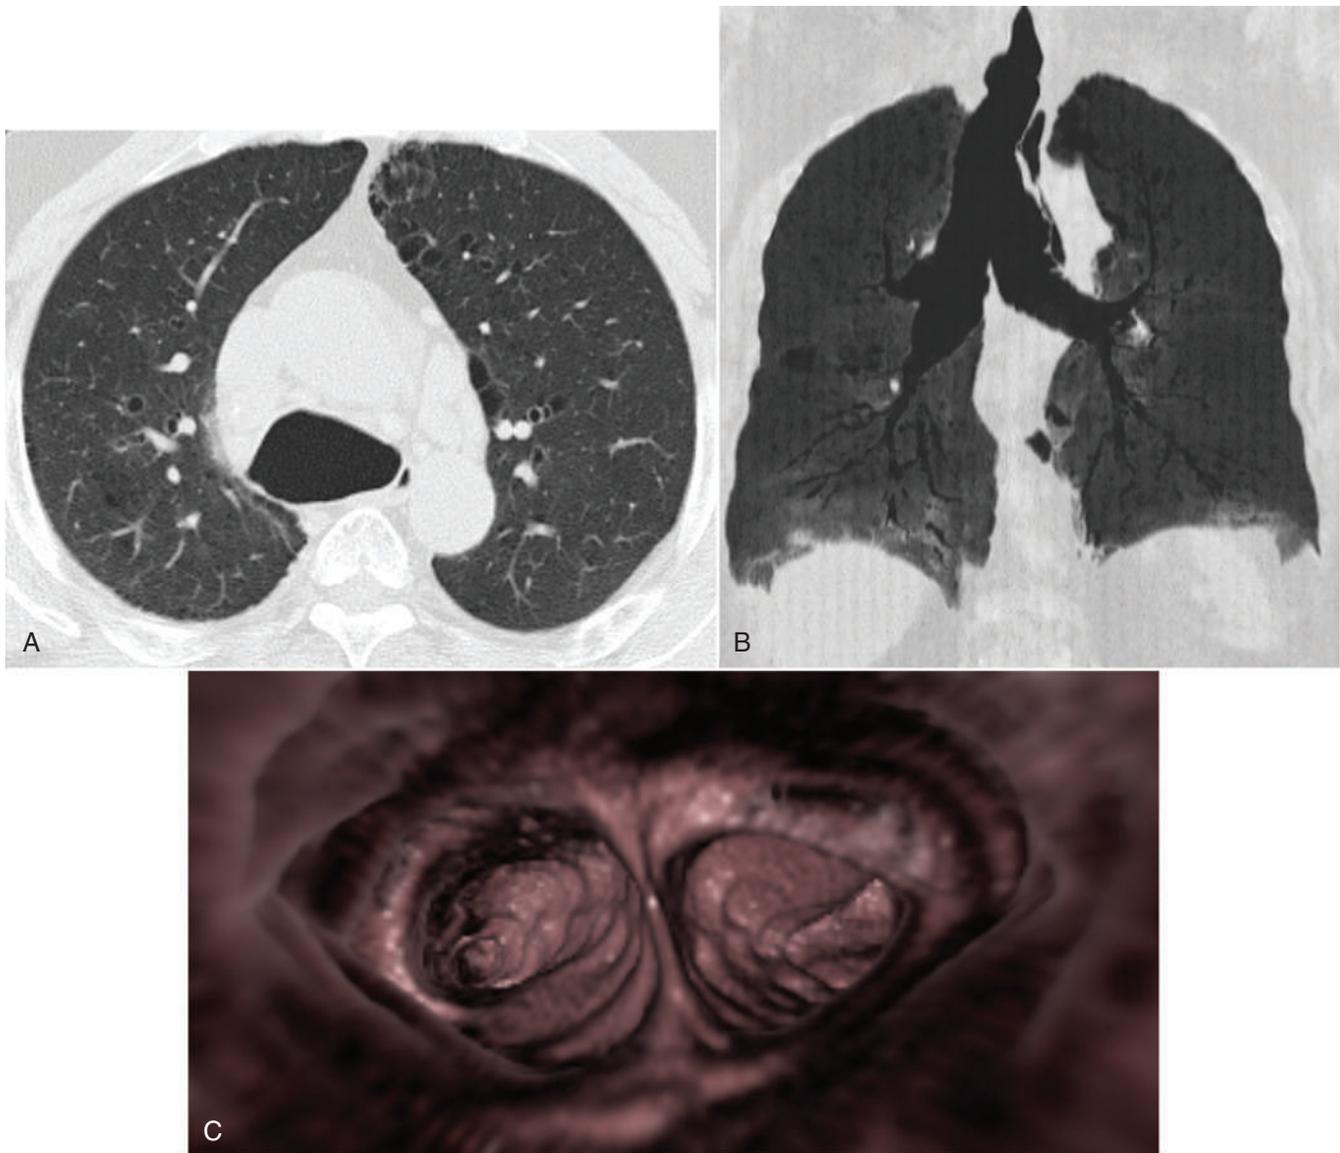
Use of 2-D and 3-D images for visualization of the trachea. Axial CT (A) image demonstrates a massively dilated trachea in a patient with tracheobronchomegaly (Mounier-Kuhn). A coronally reformatted minimum intensity projection (minIP) image (B) allows for visualization of the entire trachea and main stem bronchi. A 3-D image (C) endoluminal view of the inferior trachea looking downward at the carina with the left and right main stem bronchi located on each side of the carina. The 3-D image, termed *virtual bronchoscopy*, can aid the bronchoscopist in planning a bronchoscopic procedure.
